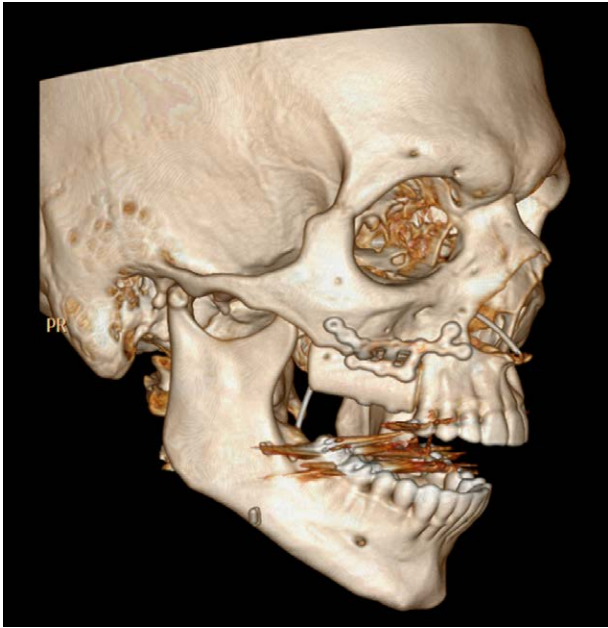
A 25-year-old man with partial maxillary defect secondary to prior resection of Ewing's sarcoma. Postoperative 3-dimensional CT image demonstrates the inset fibula construct and patient-specific laser-sintered titanium plates. The patient also underwent immediate placement of osseointegrated implant posts for future dental restoration. Here, the ability of individualized custom plates to precisely fit areas of contour is well demonstrated.
